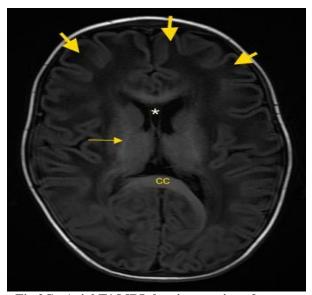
Axial T1 MRI showing sparing of corpus callosum (CC) , internal capsules (arrow). Involvement of subcortical U fibres (thick arrows) is noted. Note the cavum septum pellucidum(\*).
